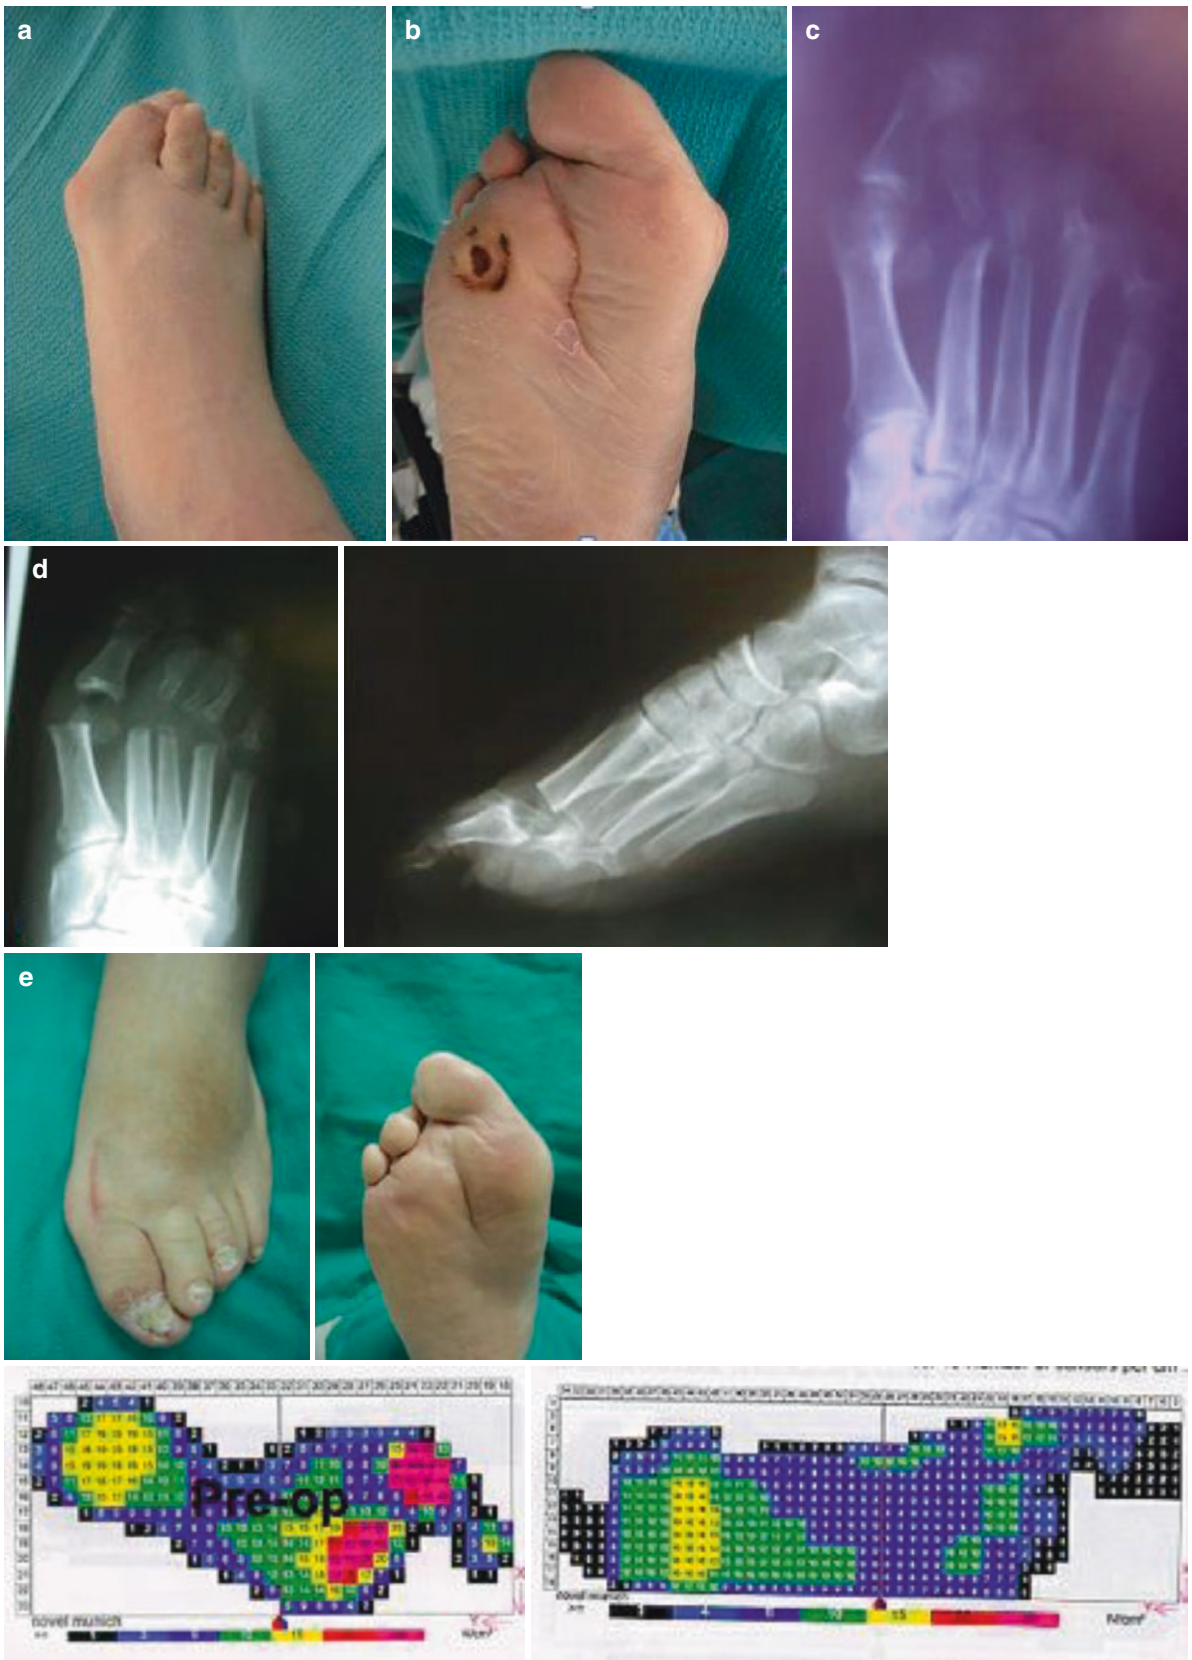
Clinical and radiographic image series of patient SR who underwent panmetatarsal head resection after revascularization for non-healing plantar neuropathic ulceration. Images A, B, C = preoperative clinical and radiographic appearance. D = Postoperative radiographic appearance. E = 5-year follow-up clinical appearance. Note ulcer-free
